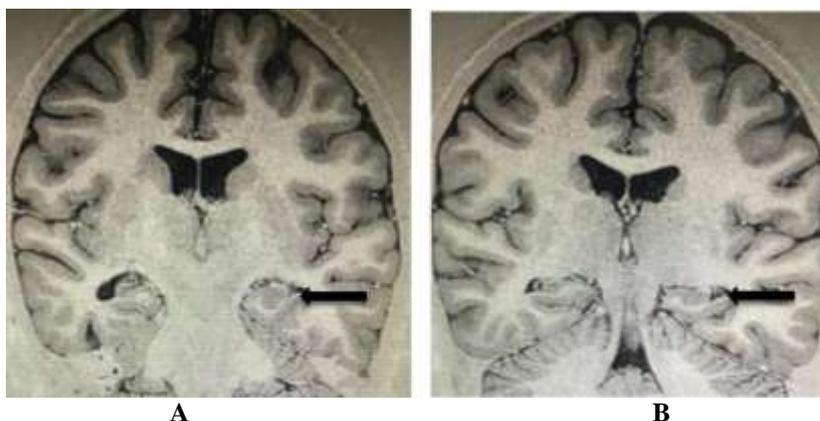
Hippocampal malrotation in a 13 year old male. MRI showing an abnormal rounded configuration of the left hippocampus with vertically oriented collateral sulcus and ipsilateral low lying fornix. Also note right sided mesial temporal sclerosis.
